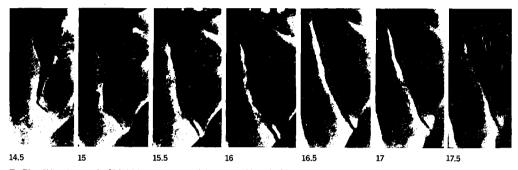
b Oblique tomography. Slight joint space narrowing, slight sclerosis of iliac side of the joint, no ankylosis and no erosions. The numbers refer to the distance between table top and centre of tomographic slice. The photographs show — in case of a narrow angulated joint – the problems typical of plain radiography and frontal tomography.
